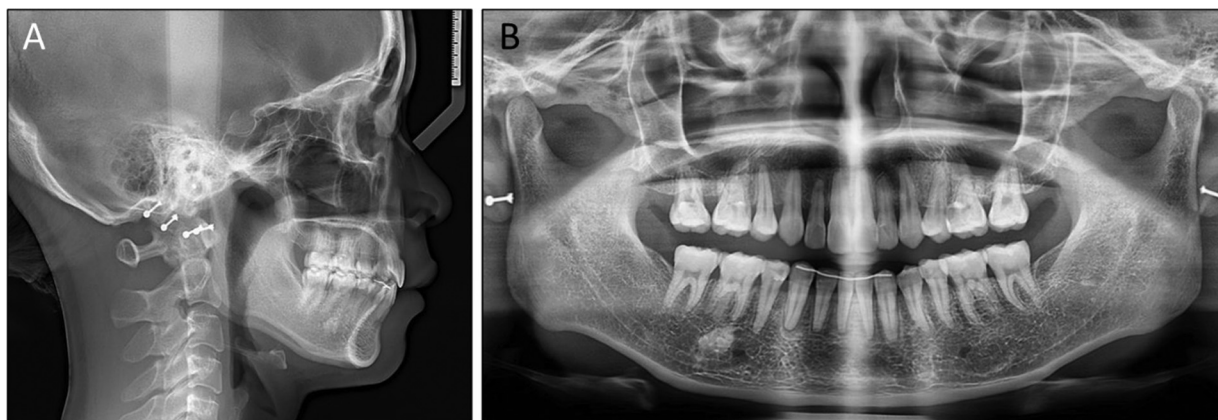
Posttreatment radiographs: (A) lateral cephalometric radiograph and (B) panoramic radiograph.
